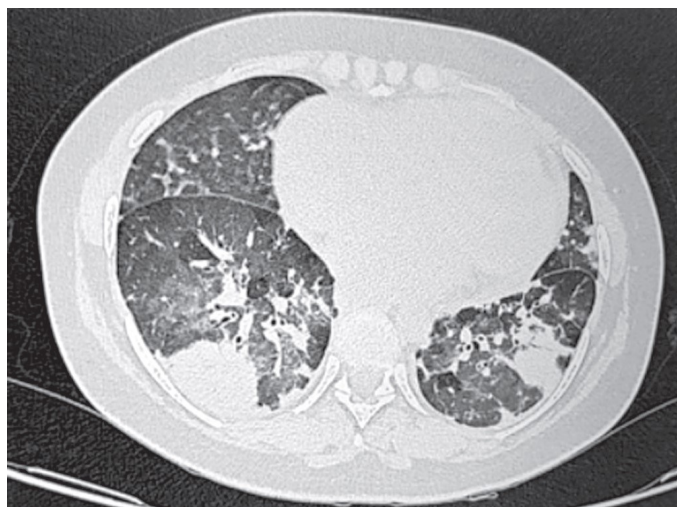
HRCT of a COVID-19 patient showing new appearance of bilateral patchy peripheral consolidation with background of focal areas of ground glass opacities and septal thickening highly suggestive of CAPA. (CAPA: COVID-19-associated pulmonary aspergillosis; HRCT: high-resolution computed tomography)
